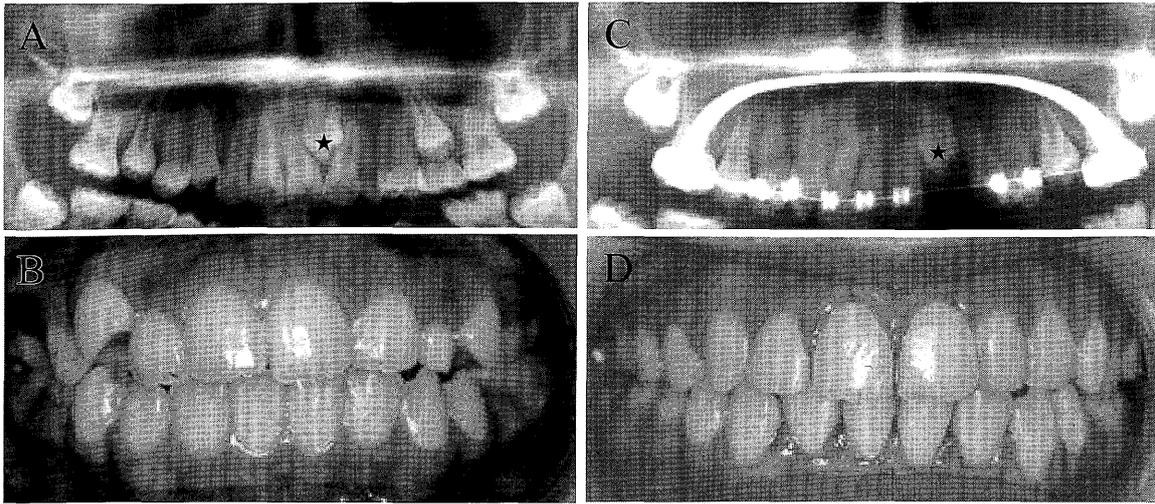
The orthopantomograms and intraoral photographs of treatment course in Case 7
